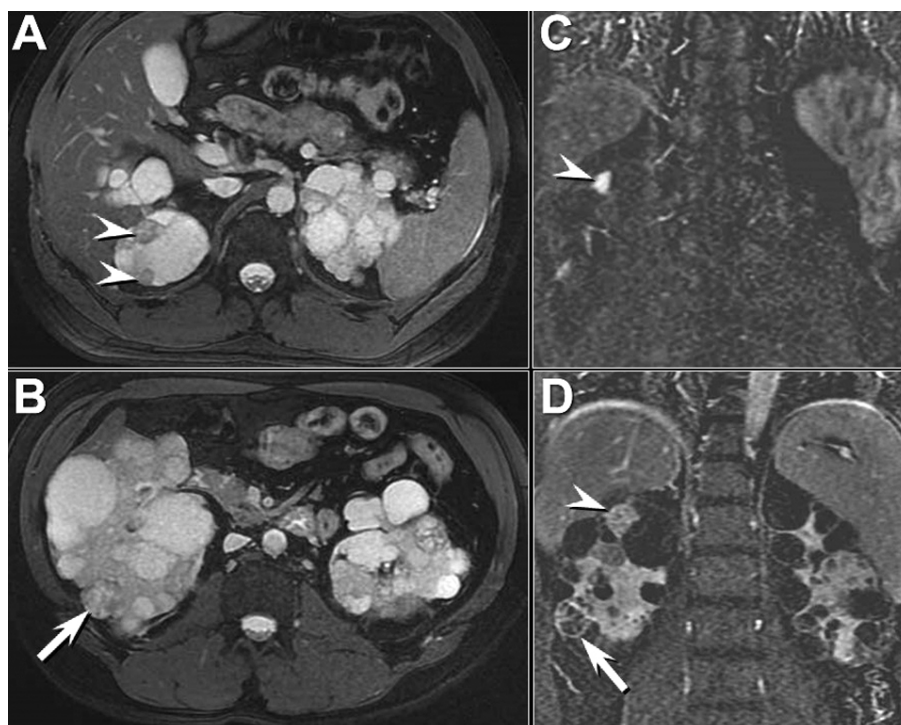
MRI of abdomen (A and B, axial steady-state free precession fat saturation images and, C and D, coronal subtraction contrast-enhanced images) shows three potentially solid, enhancing foci, two in the posterior and superior pole of the right kidney (arrowheads), and one in the lateral interpolar kidney, the latter with thick septations (arrow) that have shown slight enlargement from MR. performed one year previously.
